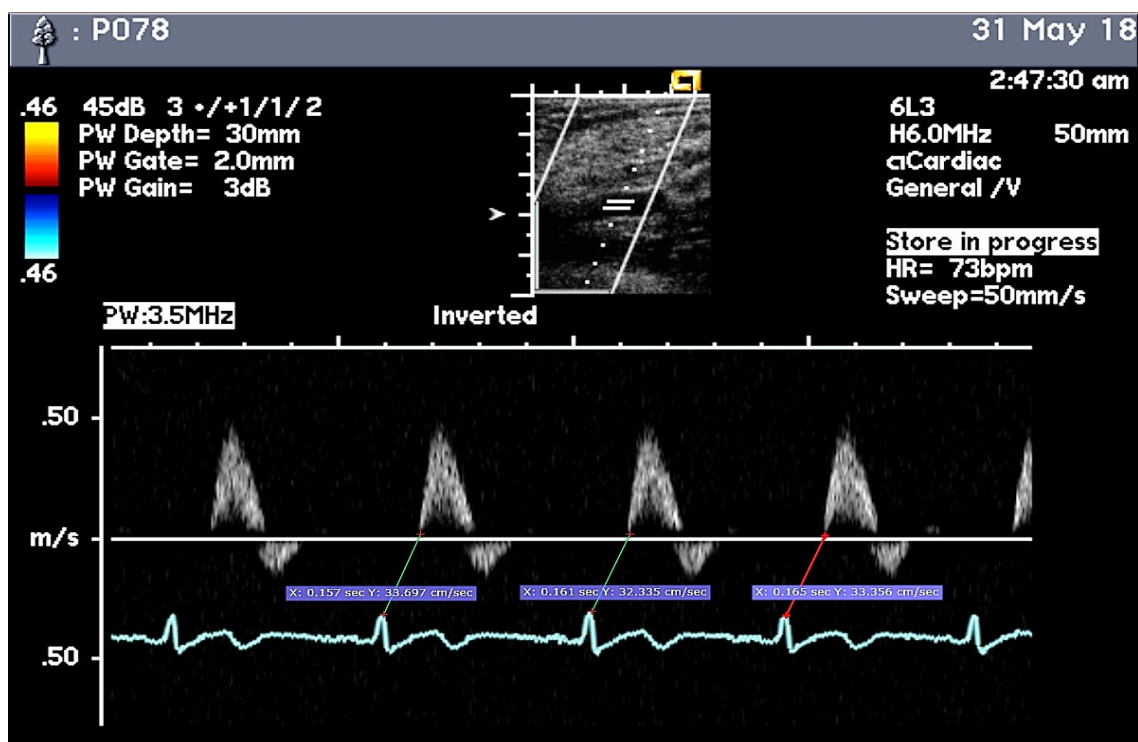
Doppler of the pulse wave at the common femoral artery
